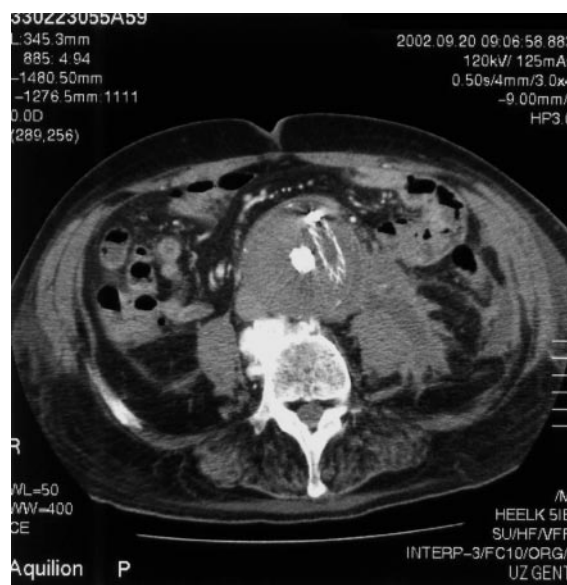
Postoperative CT-scan after insertion of an aorto-uni-iliac endoprosthesis with an occluder.
